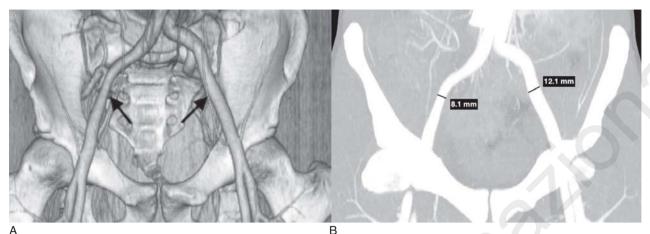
A, B - Case 1: CT-angiography showing a minimal calibre reduction of the right external iliac artery compared to the left external iliac artery with no other evident lesions (A: 3D-lumen reconstruction, B: MIP-reconstruction with EIA diameter indicated).
